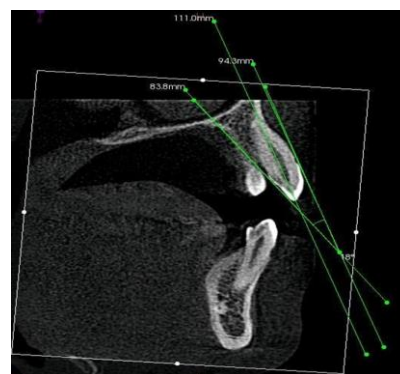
Measurement of labiolingual angle on CBCT IMAGES
